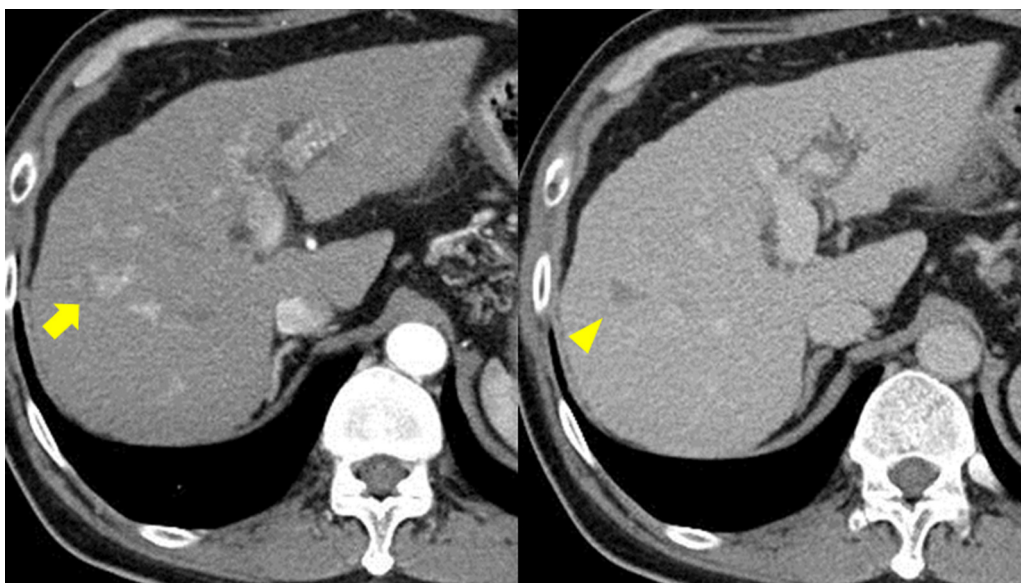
Contrast enhanced CT scan shows an enhancing 12 mm tumor in the arterial phase (arrow) and wash-out in the equilibrium phase (arrowhead), consistent with an HCC in segment 8.
